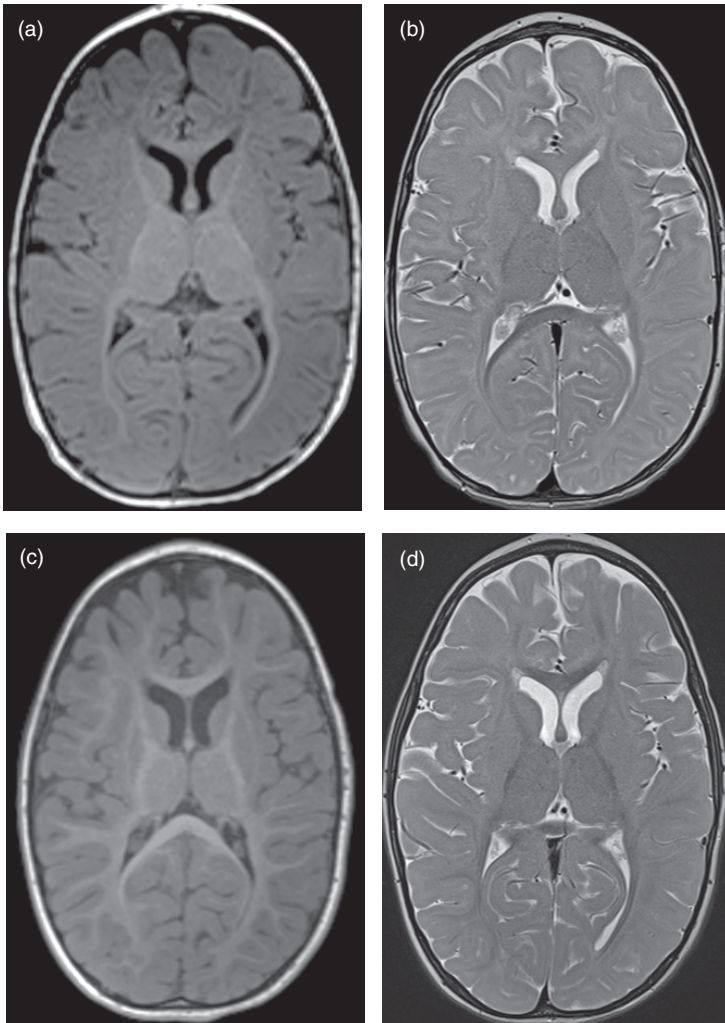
MCT8 deficient male at (a, b) 9 months and (c, d) 28 months. Initial imaging at 9 months demonstrates a profoundly delayed myelination pattern on axial T1-weighted imaging (a) though the myelination pattern is less severely delayed on axial T2-weighted imaging (b). By 28 months, myelination has progressed on (c) axial T1 and (d) axial T2 imaging. Though still abnormal the interval progress in myelination is a clue that this case does not represent a typical hypomyelinating leukodystrophy, which are generally static.
